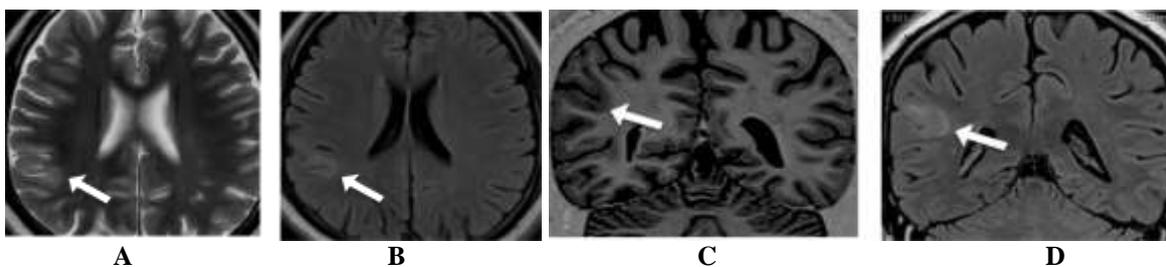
(A-D) Focal cortical dysplasia in a 15 year old male. (A) T2 weighted axial (B and D) FLAIR axial and coronal and (C) T1 inversion recovery weighted coronal images showing an area of cortical thickening in the right parietal lobe with indistinct grey-white matter differentiation and hyperintense signal in the subcortical white matter.
